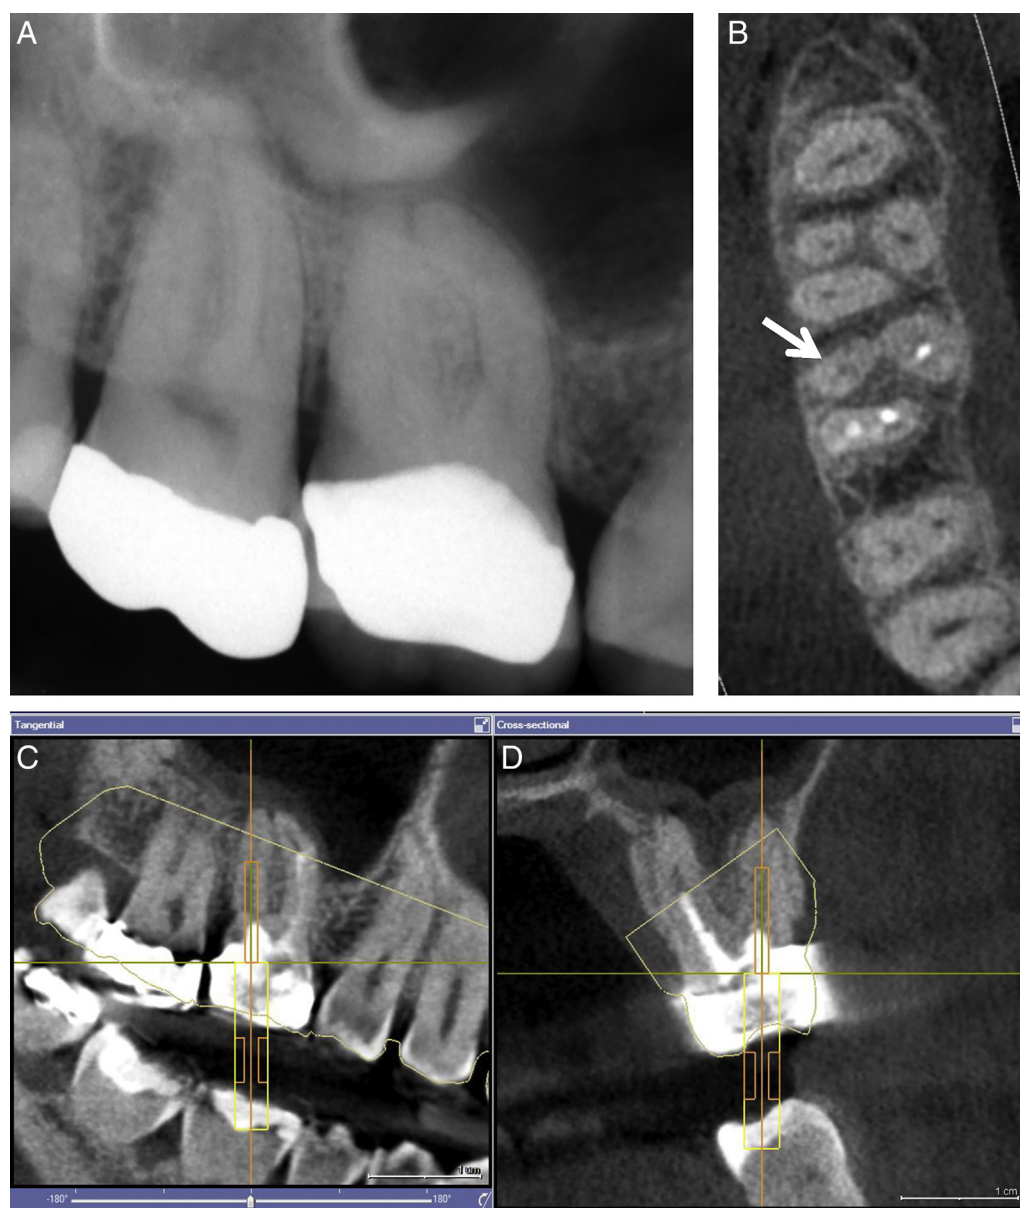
(A) Radiographic presentation of tooth #3 in need of root canal treatment because of a broadened periodontal ligament and soreness to percussion. The distal root canal is seemingly obliterated. (B) The axial view of the CBCT image exposes the region. The distobuccal canal is marked beyond the curvature, making further instrumentation possible (arrow in B); the 3 other root canals show radiopacity reflecting the in-between calcium hydroxide. (C) Tangential and (D) cross-sectioned CBCT images show that the virtual drill path (orange outlines in C and D) is placed on the images as well as the CEREC surface scan (yellow outlines in C and D) and merged with the CBCT image by the help of special software.
